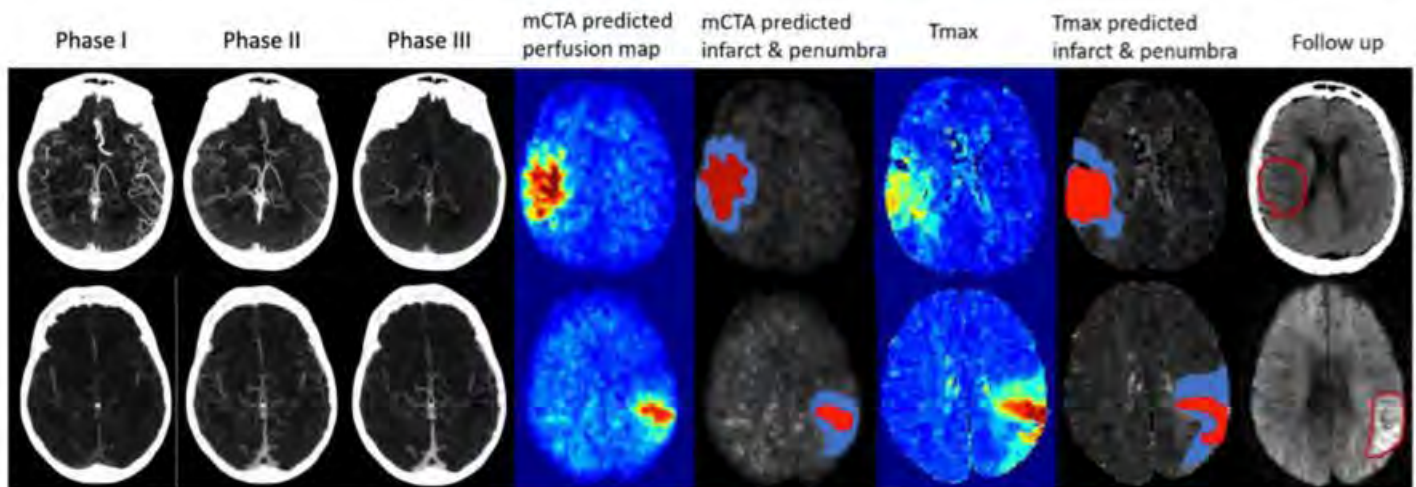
mCTA and CTP time dependent Tmax thresholded maps of predicted infarct and penumbra, compared to follow-up infarct. Rows: two separate patients, each with a MeVO. Columns (left to right): mCTA phases I-III, predicted perfusion maps, mCTA predicted core (red) and penumbra (blue) overlaid on the mCTA predicted perfusion map, CTP Tmax maps, CTP time-dependent Tmax threshold predicted infarct (red) and penumbra (blue), infarct contoured on follow-up imaging. mCTA: multiphase computed tomography angiography (mCTA);
